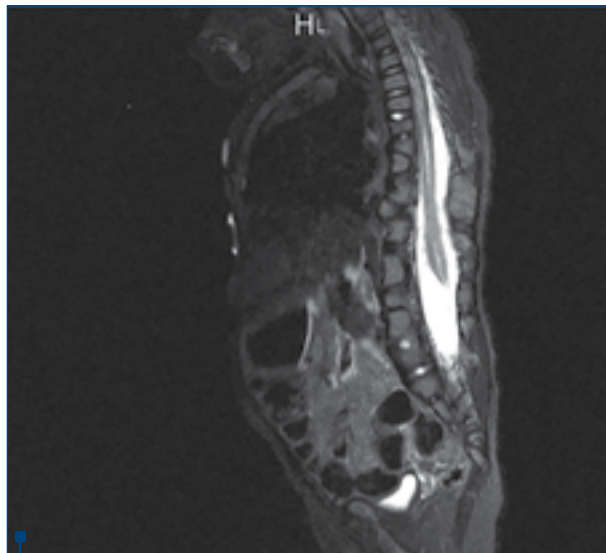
Postnatal MRI scan (at 13 months) - abnormal position of the spinal cord in the medullar canal
